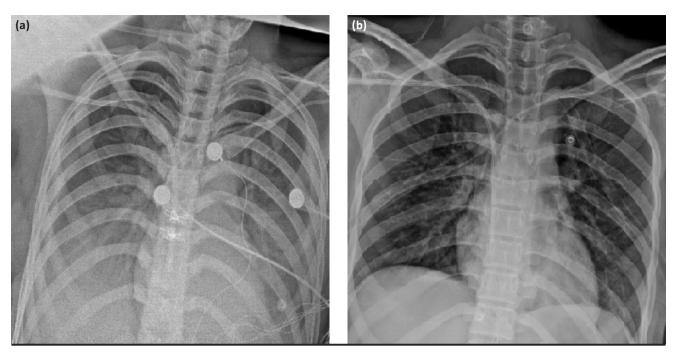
(a) Lung radiography showing closed costophrenic sinuses and pleural effusion. (b) Lung radiography following bilateral chest tube placement
